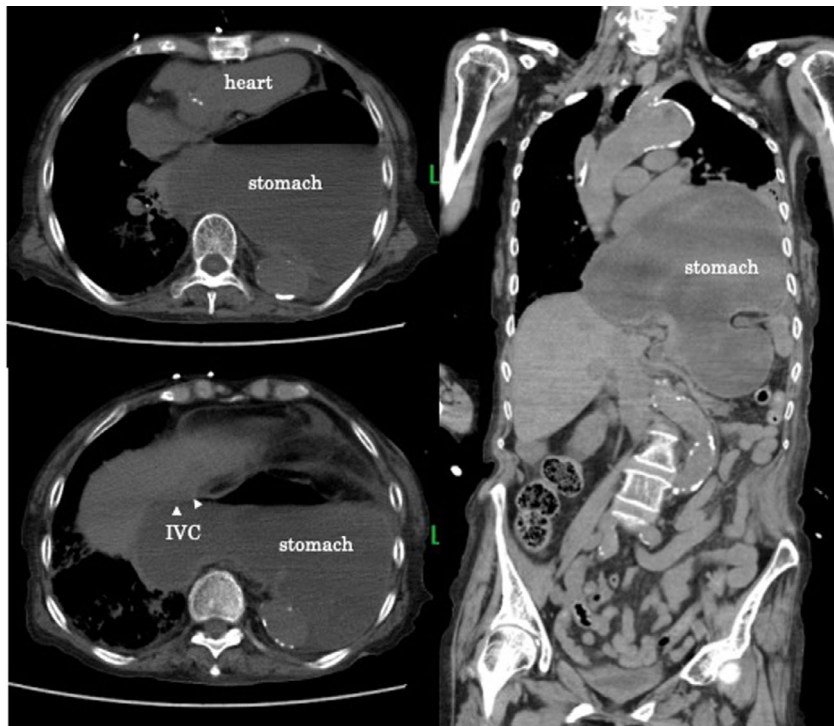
Chest and abdominal computed tomography scans (plain films) showing a significantly dilated stomach incarcerated within the mediastinum. A marked displacement of the heart and the left lung can be observed. Craniocaudal inversion of the incarcerated stomach, leading to an “upside-down stomach,” can also be visualized. IVC, inferior vena cava.
